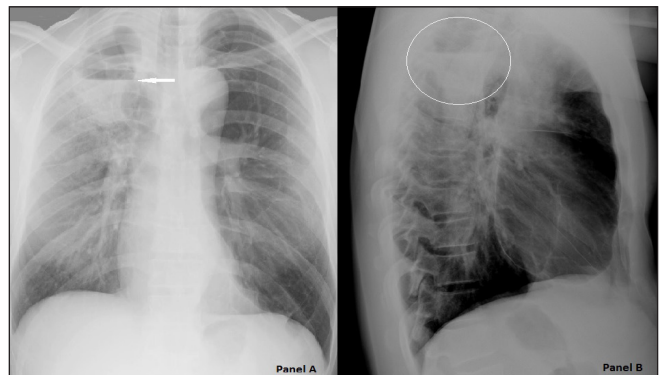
(Panel A and B) Posterior–anterior and lateral chest radiograph showing air–fluid level in the right lung. (arrows and circle)
